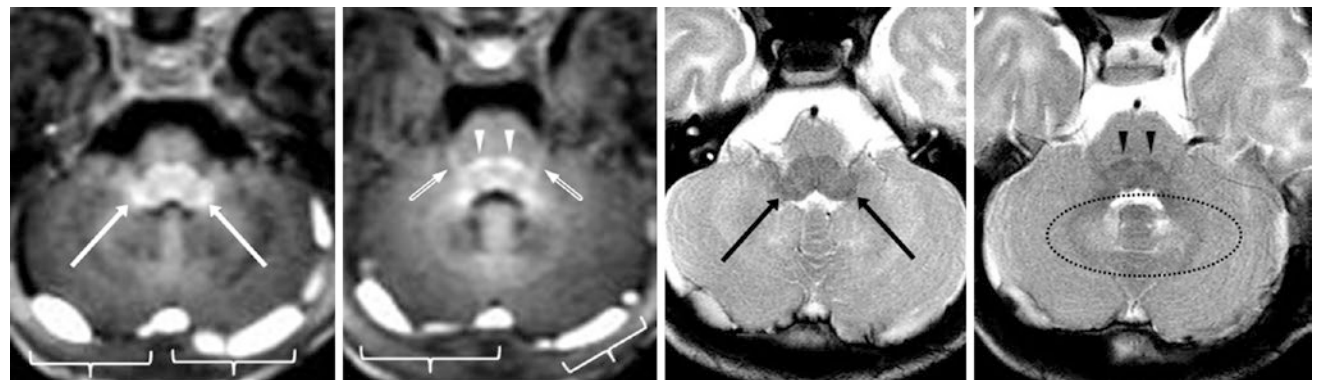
A 17-day-old term neonate had a normal 3T MRI with GE T1WI (*left images*) and SE T2WI (*right images*). Note the CNV (*beveled arrows*), ICP (*long arrows*), and ML (*arrowheads*). Note the darkening cerebellar nodulus and corpus medullare on SE T2WI (*dotted oval*). Also, note the asymptomatic posterior fossa subdural hematoma (*brackets*), which is present in many newborns
